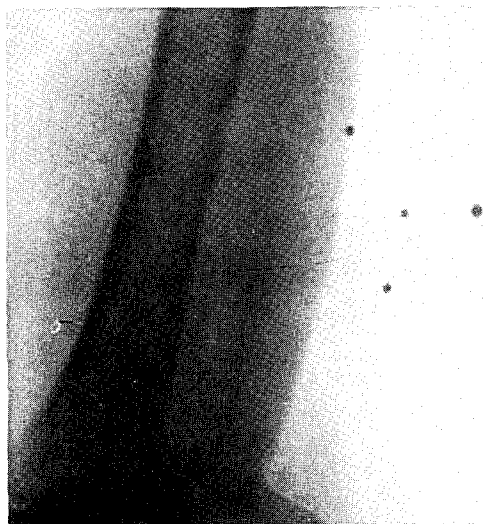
Roentgenogram (No. 119) showing butcher meat penetrated by two $\frac{1}{32}$ -inch steel spheres of different velocities. The faster sphere (velocity 2,400 f.p.s.) travels further than the slower one (velocity 1,220 f.p.s.). The spheres entered the meat at the left, and the nails at the bottom are 5 cm. apart.
